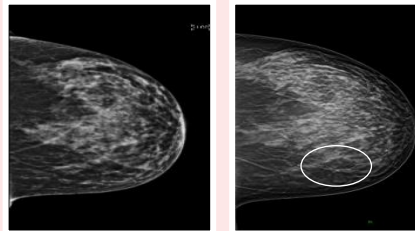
Standard 2-D mammography (L) with DBT slice demonstrating a distortion (R) initially seen on MRI (Figure 3)
